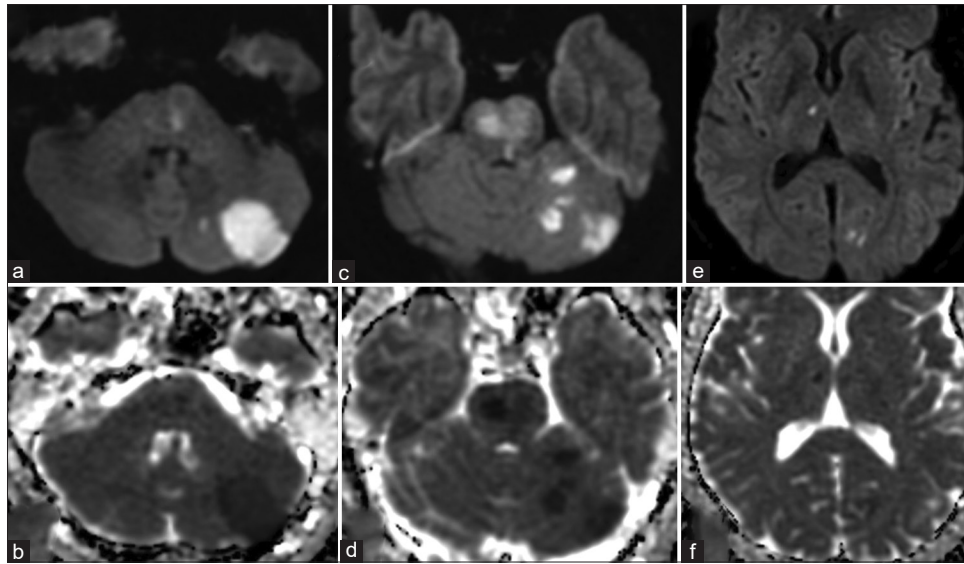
(a and b) DWI/ADC demonstrating left cerebellar infarction at the level of the pons. (c and d) DWI/ADC demonstrating bilateral midbrain and left cerebellar infarcts at the level of the midbrain. (e and f) DWI/ADC demonstrating punctate infarctions of the right thalamus and the left occipital lobe. DWI: Diffusion-weighted imaging, ADC: Apparent diffusion coefficient
